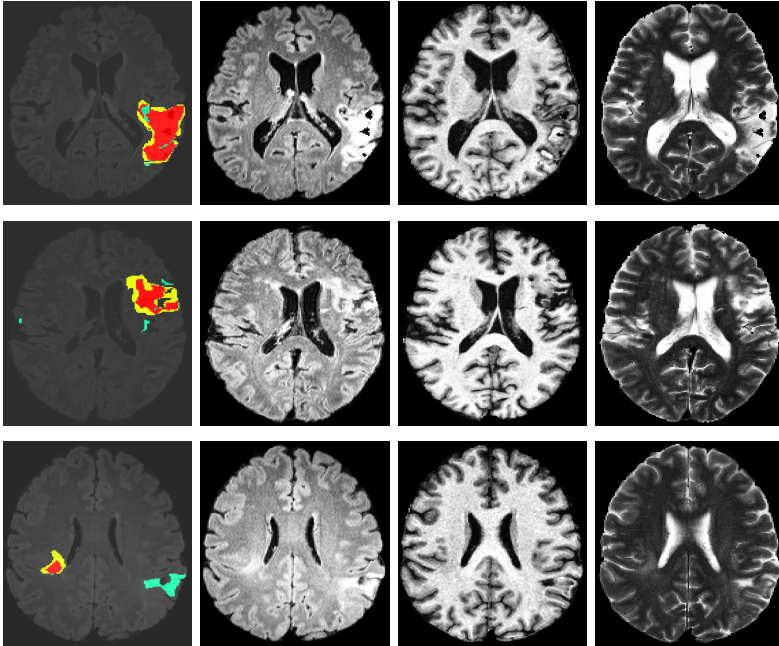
Qualitative results of ischemic lesion segmentation. Rows correspond to patients 5, 9 and 14. The 1st column shows the overlap image and the 2nd, 3rd and 4th represent the corresponding FLAIR, T1W and T2W images. ‘Red’ denotes TP, ‘yellow’ denotes FN and ‘green’ denotes FP.
